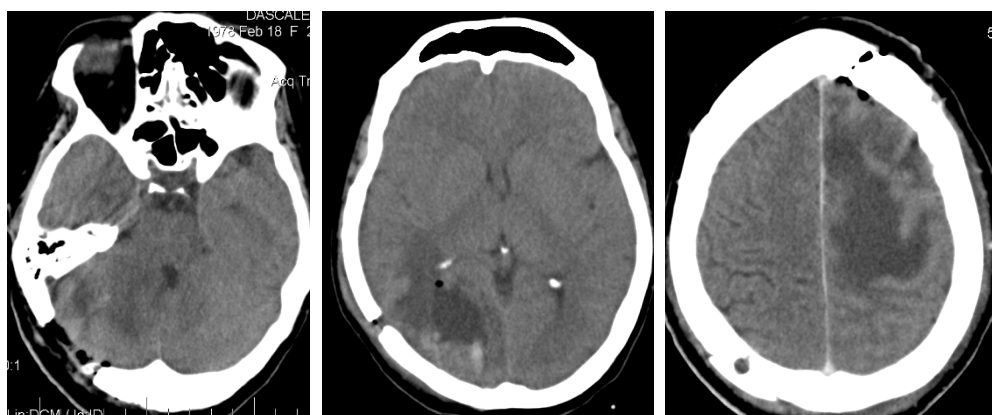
Case 1 CT scan-postoperative images
